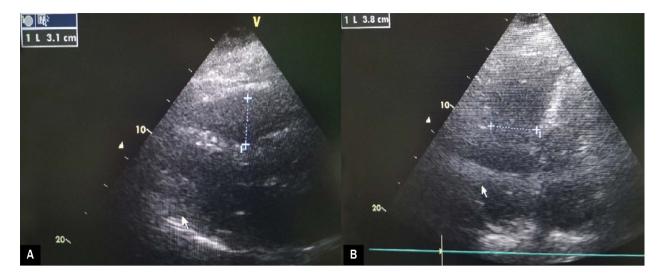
Echocardiographic examination after systemic thrombolysis: A. Normal right ventricular outflow track dimension; B. Normal right ventricular inflow track dimension
